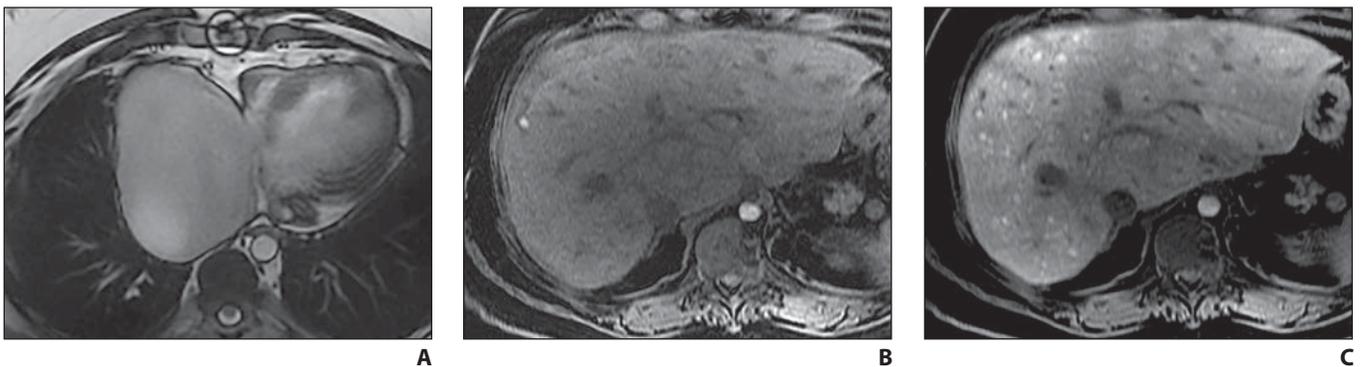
24-year-old man who underwent Fontan procedure for tricuspid atresia during infancy who later presented with regenerative nodules. A, MR image obtained at lung bases shows massively enlarged right atrium, diminutive right ventricle, patent ventricular septal defect, and enlarged left ventricle. B, Early arterial phase MR image shows hypervascular liver lesion in periphery of right hepatic lobe. C, Liver MR image obtained 20 minutes after injection of hepatobiliary contrast medium gadoxetate disodium (Eovist, Bayer HealthCare) shows multiple regenerative nodules that retain contrast medium.
